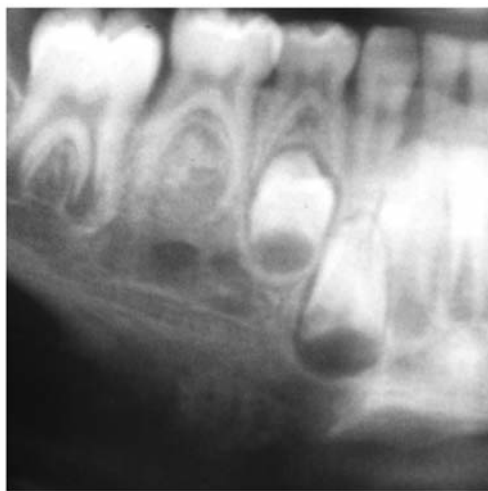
Detail of panoramic radiograph at the time of first investigation. The inferior ram of the mandible showed an expansive bone-like mass with osteolytic zone.
